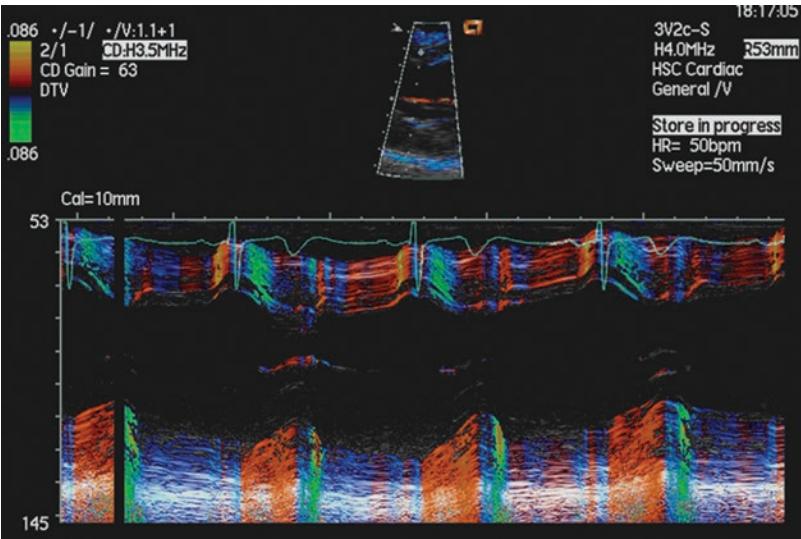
Doppler signal Amplitude is determined by the number of scatterers, and is independent of their velocities
